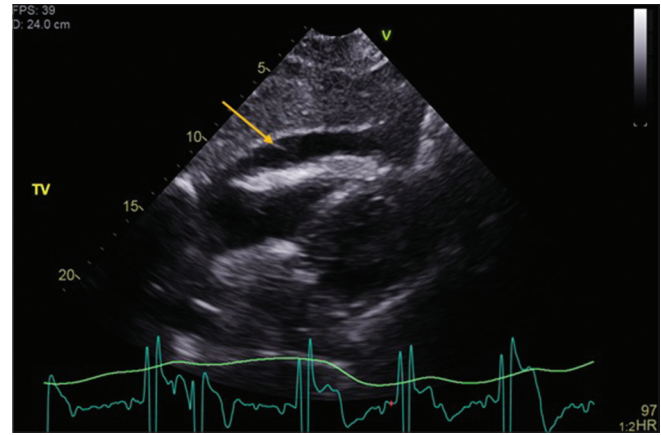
Transthoracic echocardiogram after removal of pacing wires, yellow arrow shows pericardial effusion around the right ventricle
